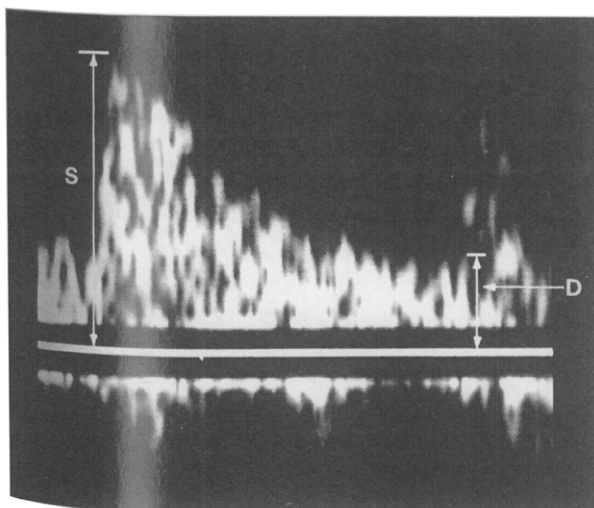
Method of obtaining resistive (Pourcelot) index from arcuate artery Doppler profile. $RI = (S-D)/S$, where S = height of systolic peak (to baseline), D = height of diastolic trough (to baseline), and RI = resistive index.
